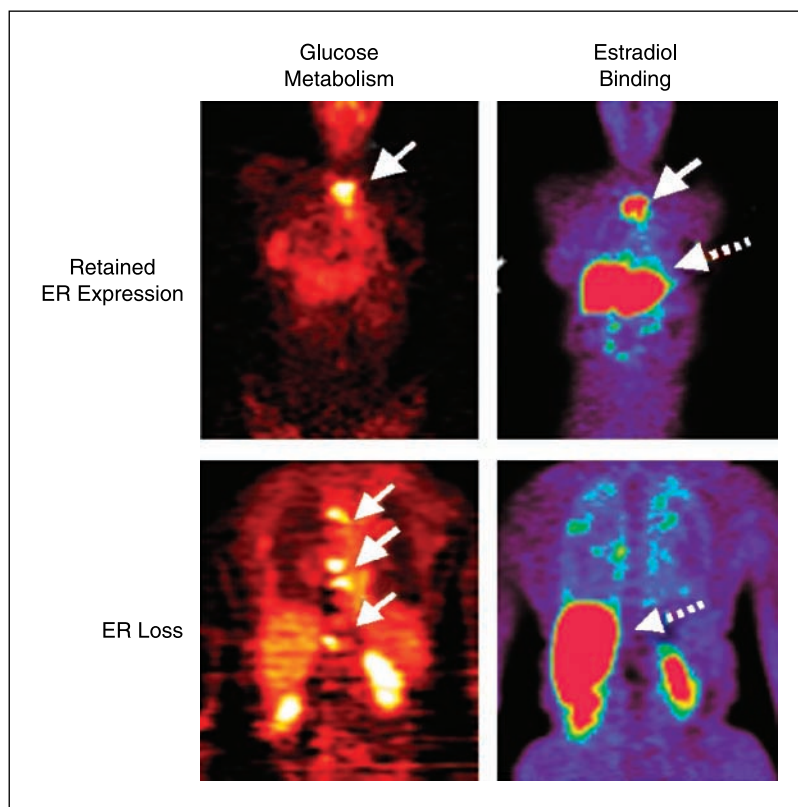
Coronal images of glucose metabolism (*left*) and estradiol binding (*right*) obtained by FDG and FES PET, respectively, in two patients with recurrent breast cancer. Solid arrows, tumor sites; dashed arrows, the normal liver, the site of FES metabolism, in both FES images. Both patients had recurrent disease from ER-expressing primary breast cancers and were treated with hormonal therapy. Top, PET images of the patient show high-level estradiol binding in a sternal metastasis, indicating retained ER expression. This patient had an early and sustained response to letrozole. Bottom, the patient had multiple active bone metastasis on the FDG-PET scan but no estradiol binding, indicating a loss of functional ER. This patient failed hormonal therapy and had disease progression on multiple different hormonal regimens.
